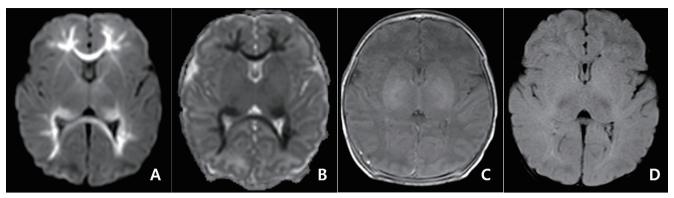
Magnetic resonance imaging obtained 3 days after the onset of seizures in a term-newborns with seizures in 6th day and rotavirus infection. Diffusion-weighted imaging (A) and apparent diffusion coefficient map (B) show restricted diffusion in the periventricular white matter, corpus callosum, and optic radiation with symmetry. These findings were not apparent in T1-weighted spine echo sequence (C) and T2-weighted fluid-attenuated inversion recovery images (D) (unpublished data from Gyeongsang National University Hospital).
